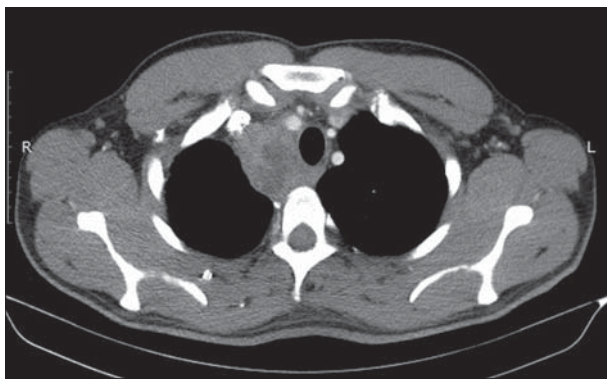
Contrast-enhanced axial CT scan of the thorax showing a well-circumscribed mass located in the superior and anterior mediastinum, measuring 37 × 39 × 59 mm, encasing the superior vena cava and the right brachiocephalic vein
